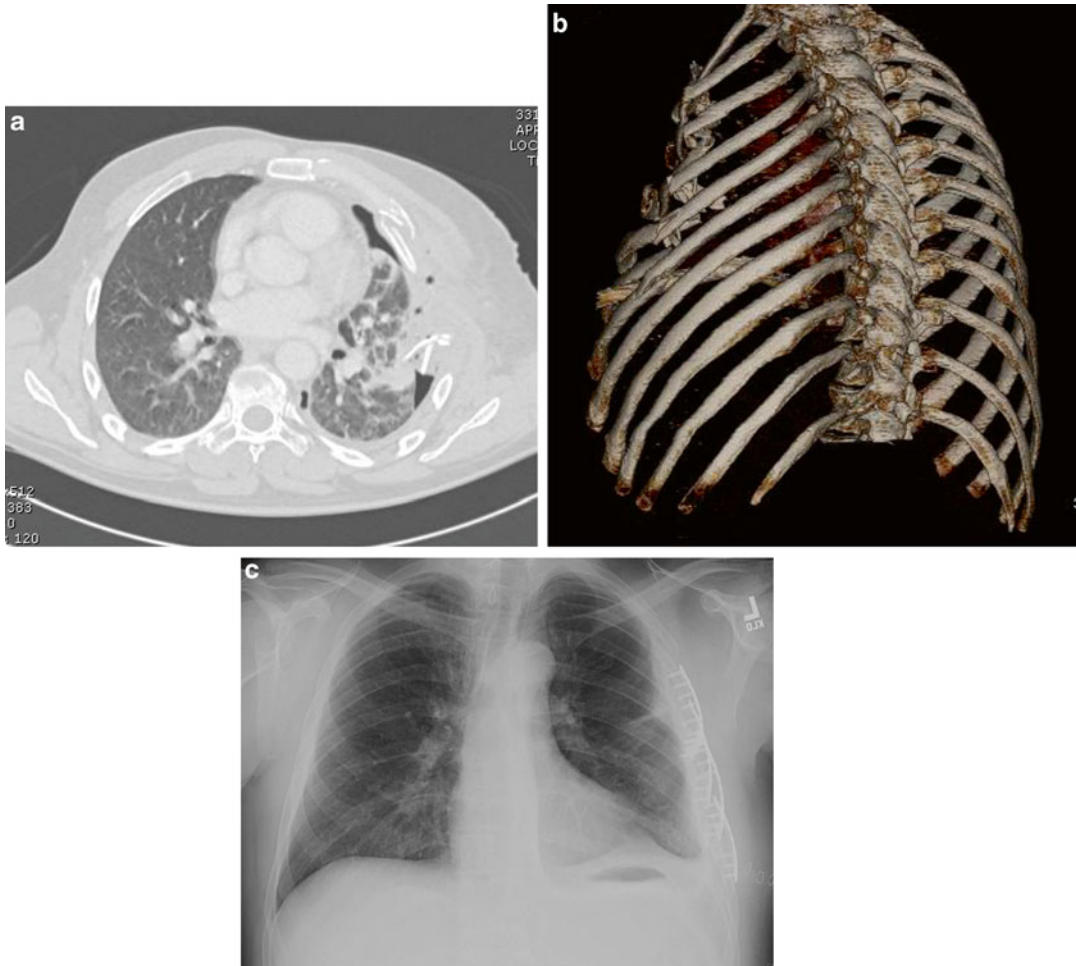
(a) A CT scan demonstrates severe chest wall displacement with a flail segment in a polytrauma patient. There is an associated pneumothorax and significant lung parenchymal injury from displaced and penetrating ribs. (b) The 3D CT scan reconstruction demonstrates the anterolateral location of the flail segment. This type of 3D reconstruction is a valuable tool
